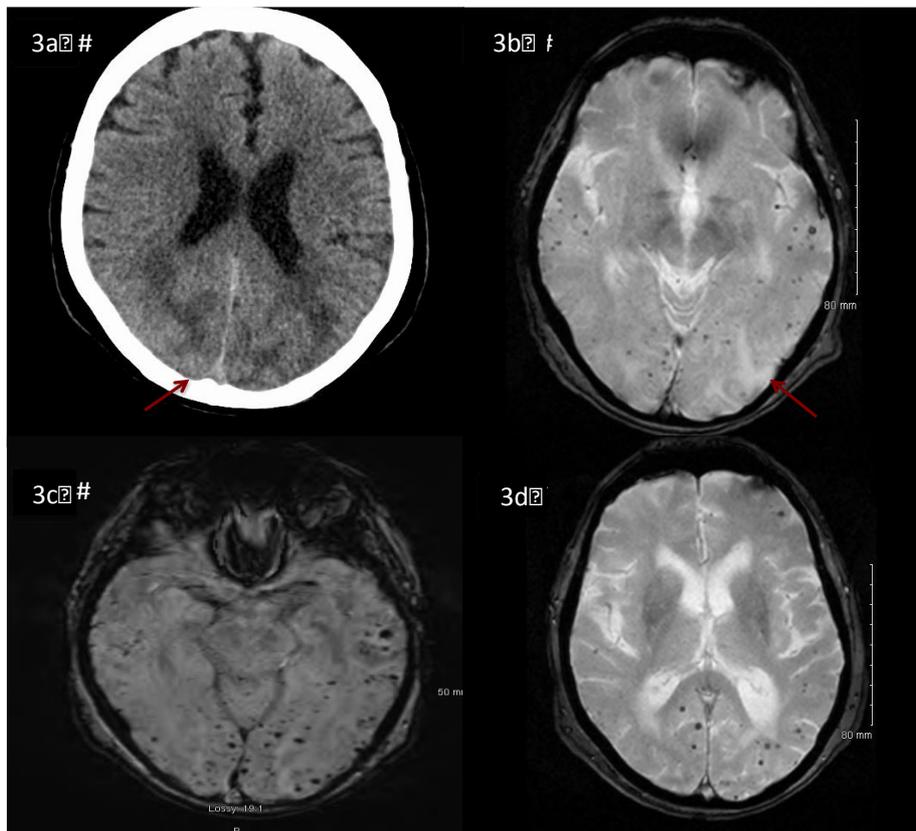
Non-contrast axial CT brain showing asymmetrical vasogenic oedema involving bilateral occipital lobes with a 5mm hyperdense area in right occipital lobe .
